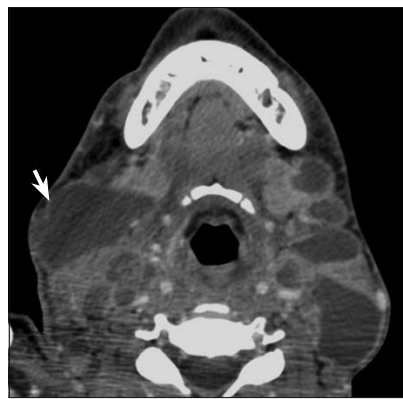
CT image of the lower neck again shows similar pathologic nodes involving multiple nodal chains. The largest node (*arrow*) was aspirated and revealed acid-fast bacilli.
